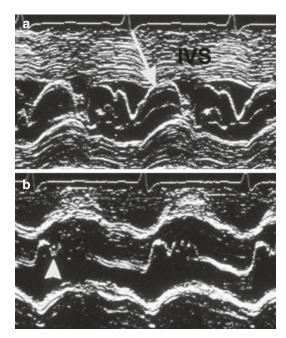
A representative M-mode echocardiogram from a patient with hypertrophic cardiomyopathy highlighting the four main echocardiographic features of the condition. (a) mid-systolic closure of the aortic valve (arrowhead), (b) systolic anterior motion of the mitral valve (arrow) and asymmetric left ventricular hypertrophy together with a small, vigorously contracting left ventricle
